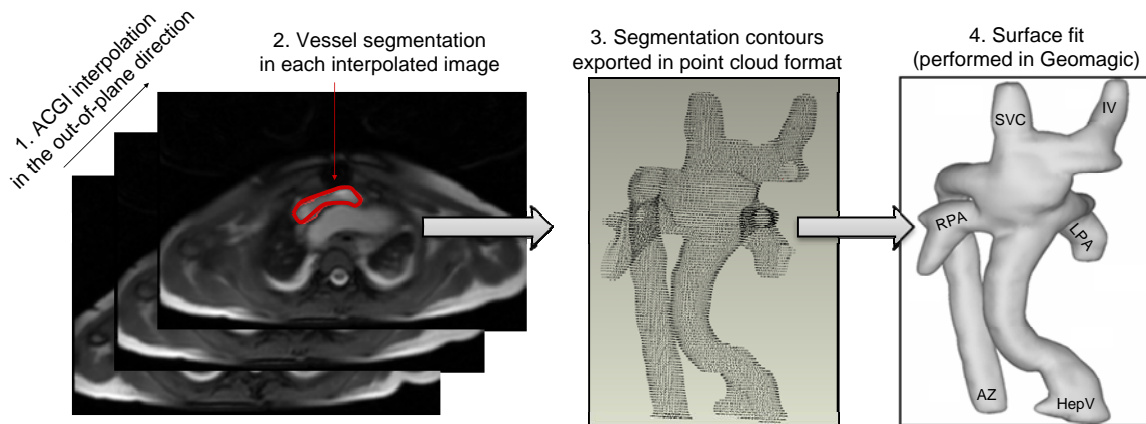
Main steps for the reconstruction of a TCPC anatomy from a stack of axial MRI, performed using a combination of in-house interpolation and segmentation software and Geomagic Studio 9.0 (Geomagic Inc., NC, USA) for the surface fit.
